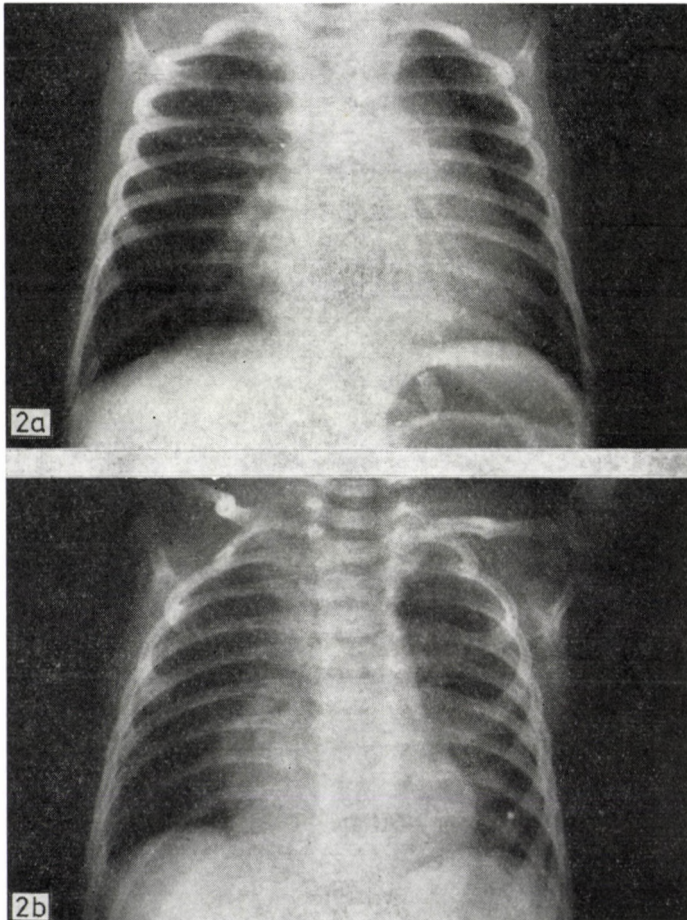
Chest X-rays of SGA infant with hypoglycaemia and cardiomegaly. a) At 2 days of age showing enlarged heart; b) at 5 days of age showing normal heart
